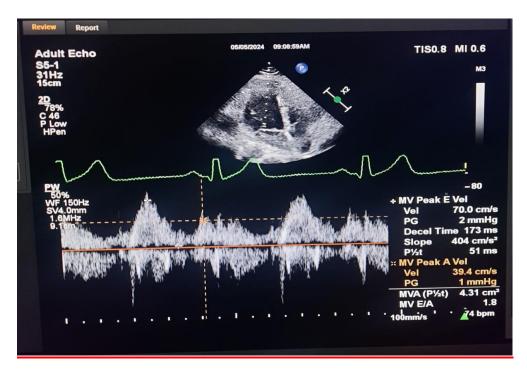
At the mitral valve's leaflet tips the pulsed wave doppler was utilized to detect peak velocity of early diastolic flow of the mitral valve.
